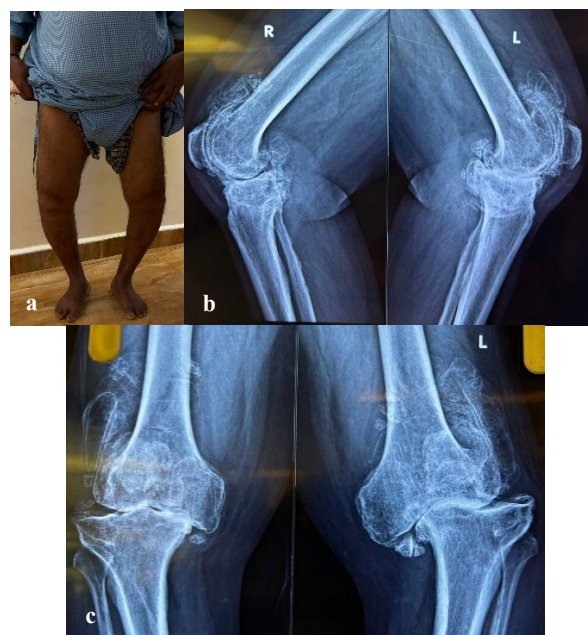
(a) Pre-op patient stance (b) pre-Op X-ray B/L knee lateral view and (c) pre-op X-ray B/L knee AP view.
